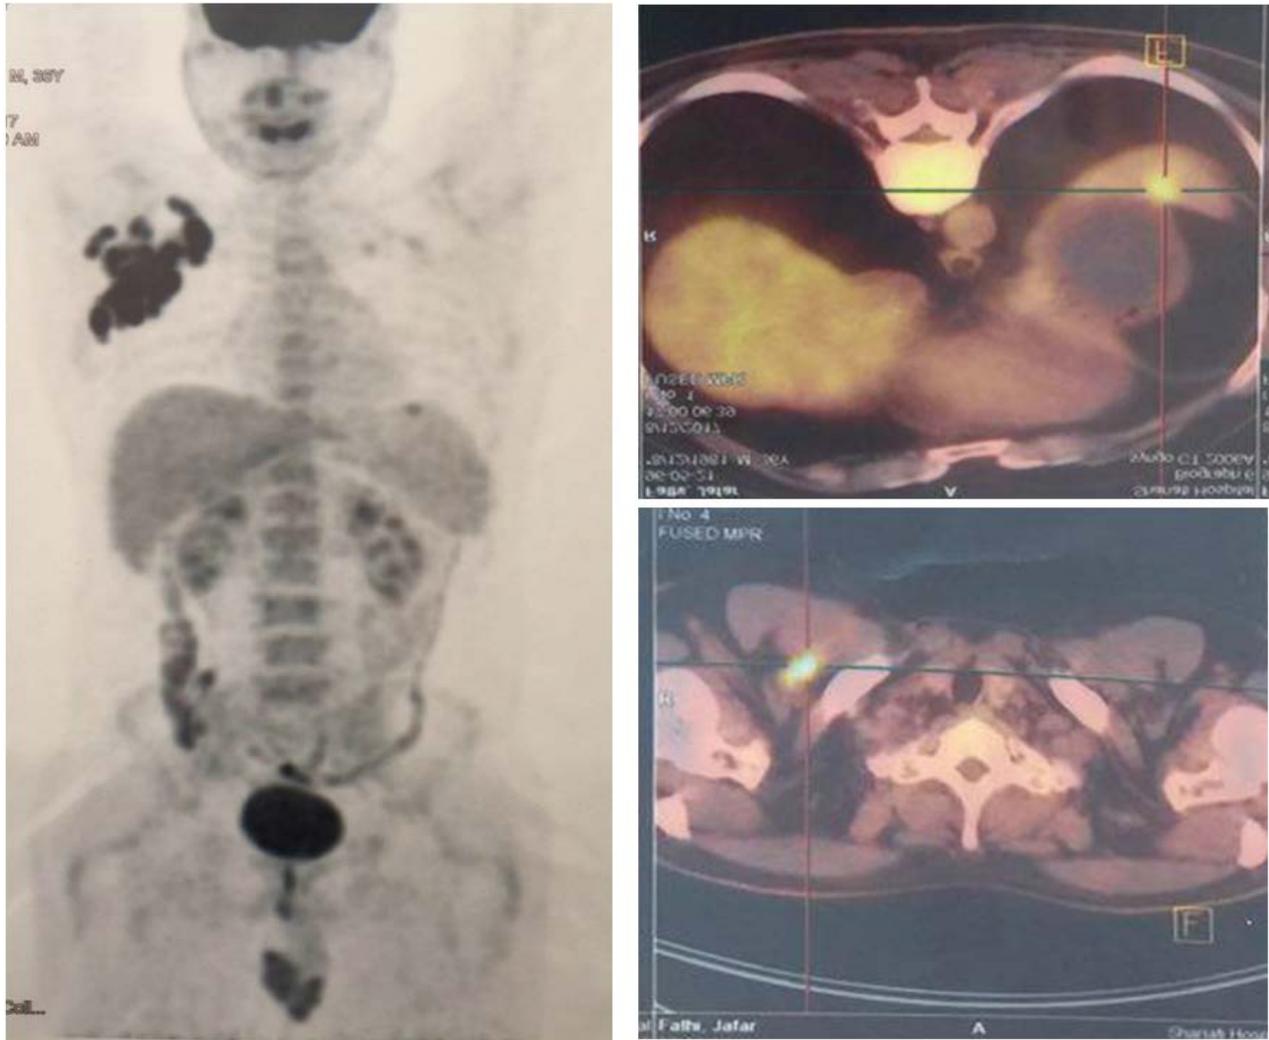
PET/CT scan images
